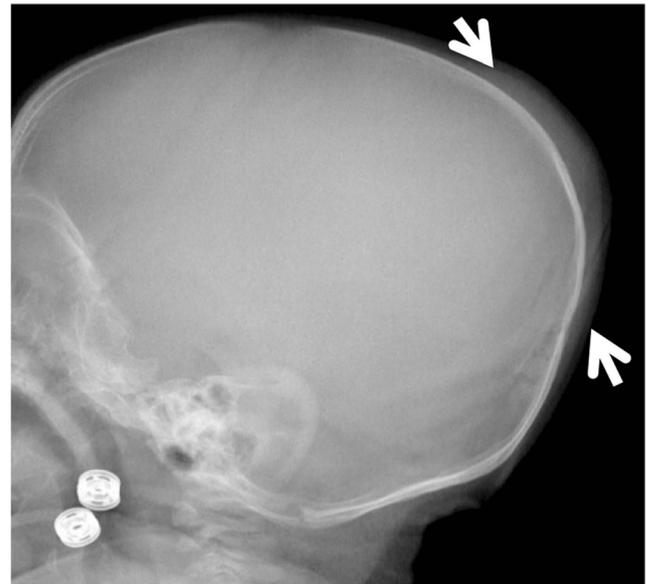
Skull X-ray of case 2 shows soft tissue swelling in parieto-occipital region (arrows)
